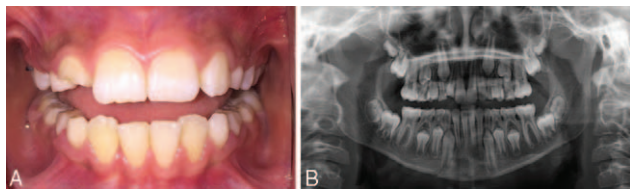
(A) Intraoral view showing excellent occlusal alignment of the mandibular right lateral and central incisors. (B) Panoramic radiograph taken 4 weeks postoperatively showing good reduction and healing of the fracture.
